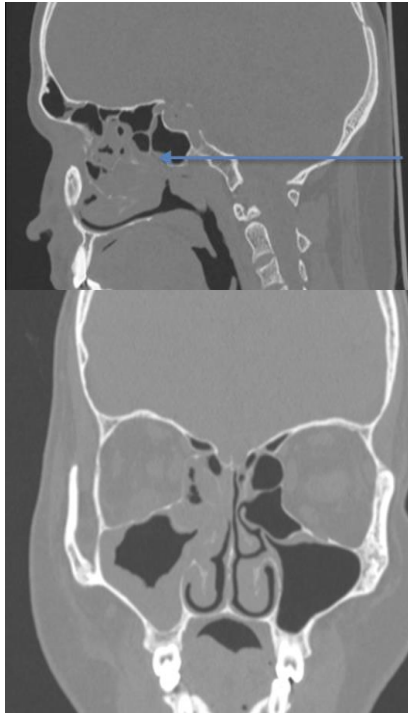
CT plain coronal and sagittal reformatted images of paranasal sinus showing diffuse circumferential mucosal thickening involving the right maxillary sinus with extension to the right anterior ethmoidal sinuses with obliteration of the osteo-meatal complex.
